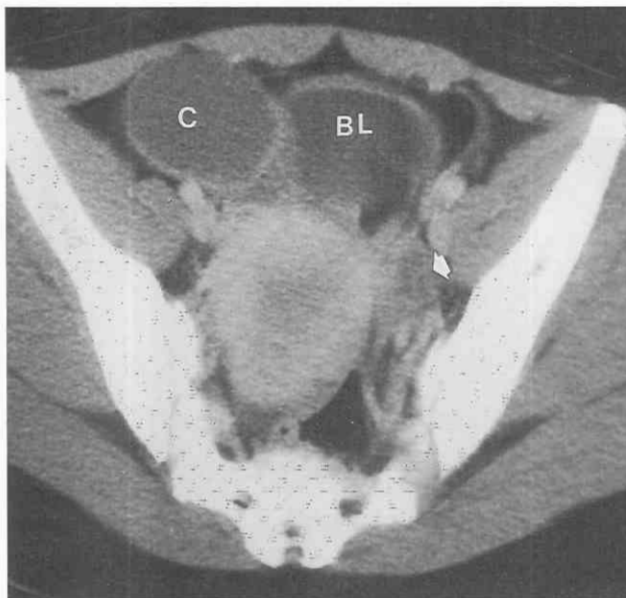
Benign ovarian cyst. Contrast-enhanced CT scan of a 14-year-old girl with pelvic pain and a mass shows a well-circumscribed, round, nonenhancing mass of near-water attenuation arising from the right ovary consistent with a cyst (C). The cyst measures 5 × 4 cm. Note the normal uterus and left ovary (arrow). BL, bladder.
